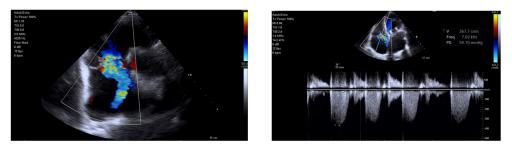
c.6. Severe tricuspid regurgitation and calculating of pulmonary systolic arterial pressure (54 mmHg) (left: color Doppler, parasternal short-axis; right: CW Doppler, 4-chambers view)
